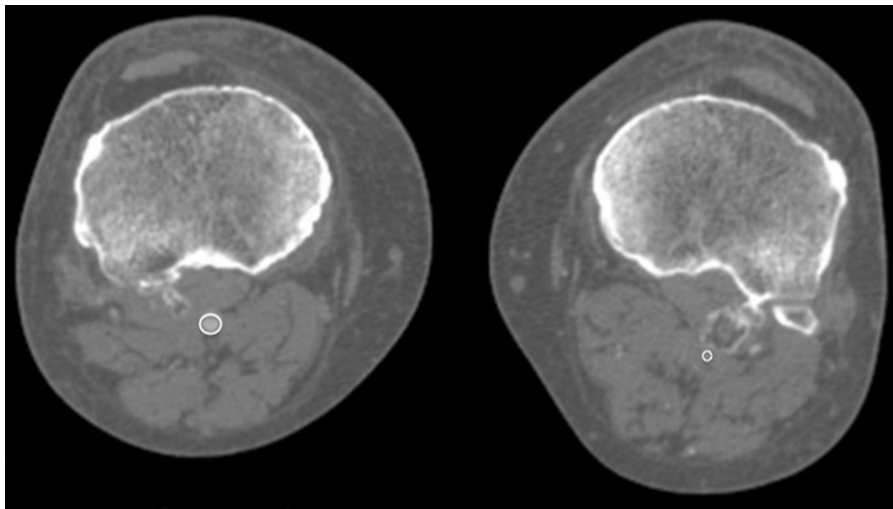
CT angiogram of MMII. Axial slice. Posterior displacement of the left popliteal artery (circles).
